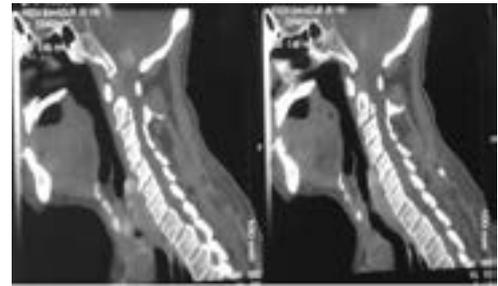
CT scan showing Benzel type 2 C2 body fracture.
